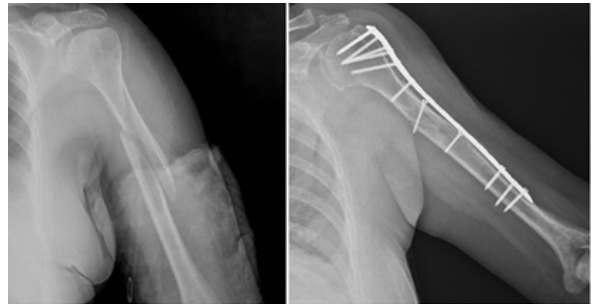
Preoperative anteroposterior radiograph showing a long spiral metadiaphyseal fracture of the left humerus with a large lateral butterfly fragment (left side). Post-operative anteroposterior and lateral radiographs of the left humerus at 4-month follow-up showing union (right side).
